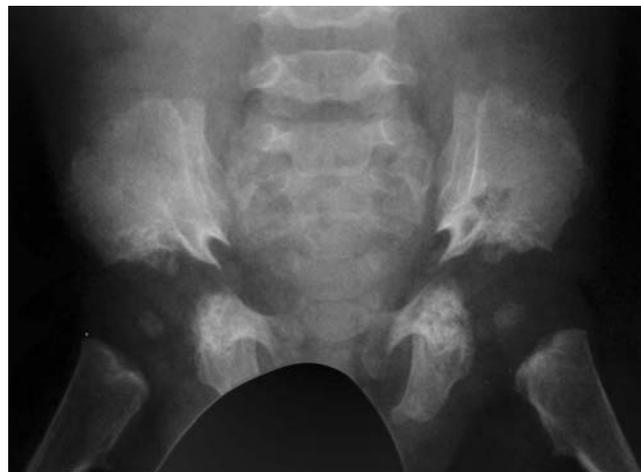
The pelvic radiographic findings in asphyxiating thoracic dysplasia (ATD) are important diagnostic features. This radiograph shows the typical pelvis of ATD with narrow sacrosciatic notches and trident appearance of the acetabular roof (radiograph provided by Dr. Elke Schaefer).
